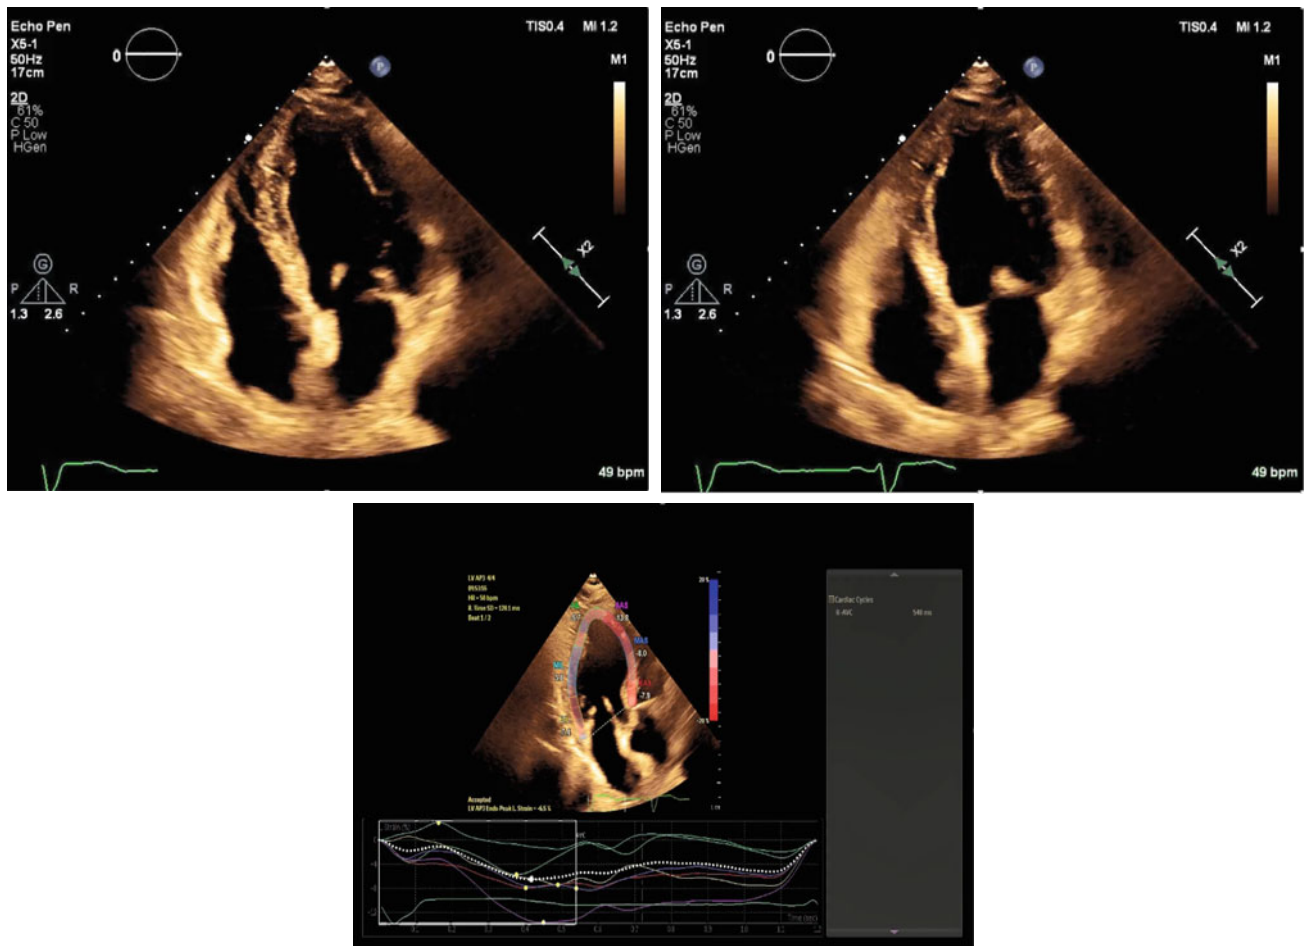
Baseline echocardiogram (top): LVEF 30–35% with dyskinesia from LBBB in apical four-chamber views (end diastolic frame, left), and end systolic frame (right). Baseline global longitudinal
